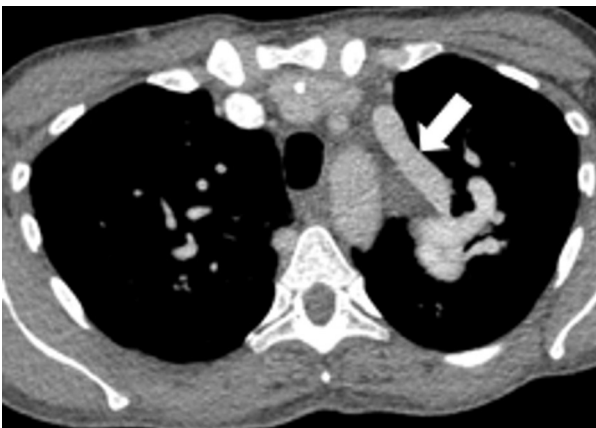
CT chest scan in the mediastinal window demonstrating partial anomalous pulmonary venous return (white arrow).
